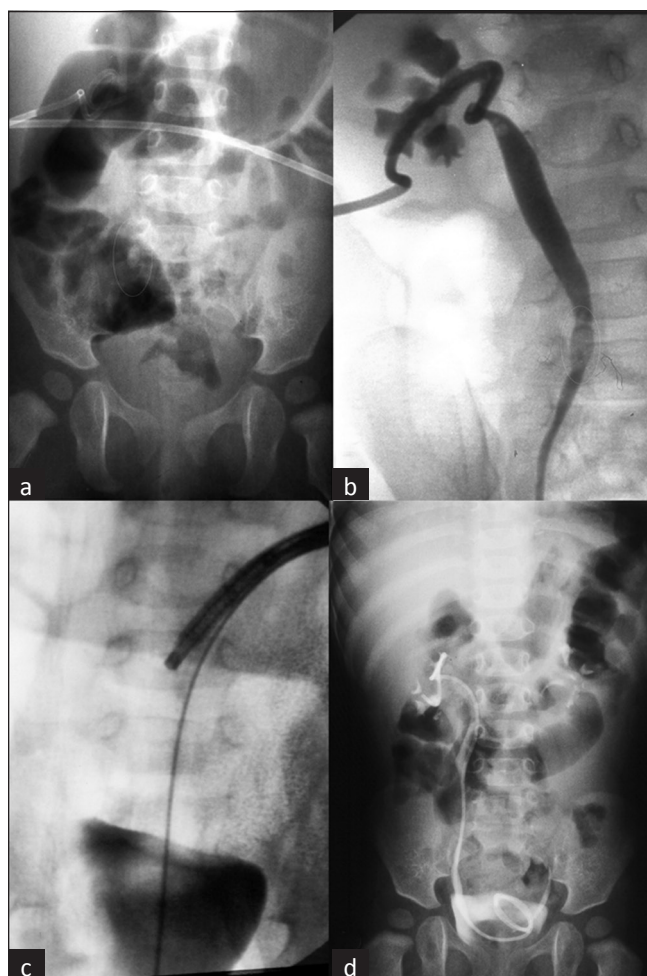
Management of an 11-month-old female infant who presented with urosepsis secondary to an obstructing right-sided mid-ureteral calculus (a) KUB demonstrating radiodense calculus on the right side (b) Antegrade nephrostogram (c) Intra-operative radiograph demonstrating antegrade ureteroscopy (d) Post-operative intravenous pyelogram demonstrating the indwelling ureteral stent
